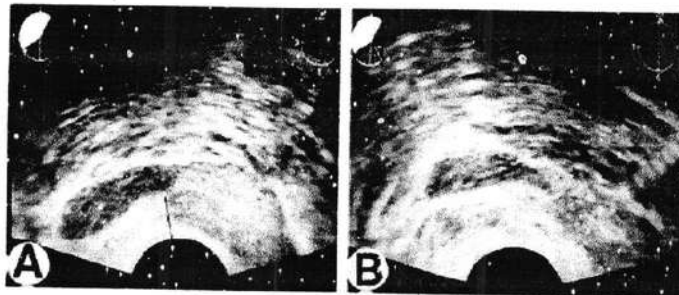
Transrectal ultrasound of prostate and seminal vesicles. A) Arrows indicate the injection of lidocaine, B) After injection of the seminal vesicles are lifted and separated from the perirectal fat.³
